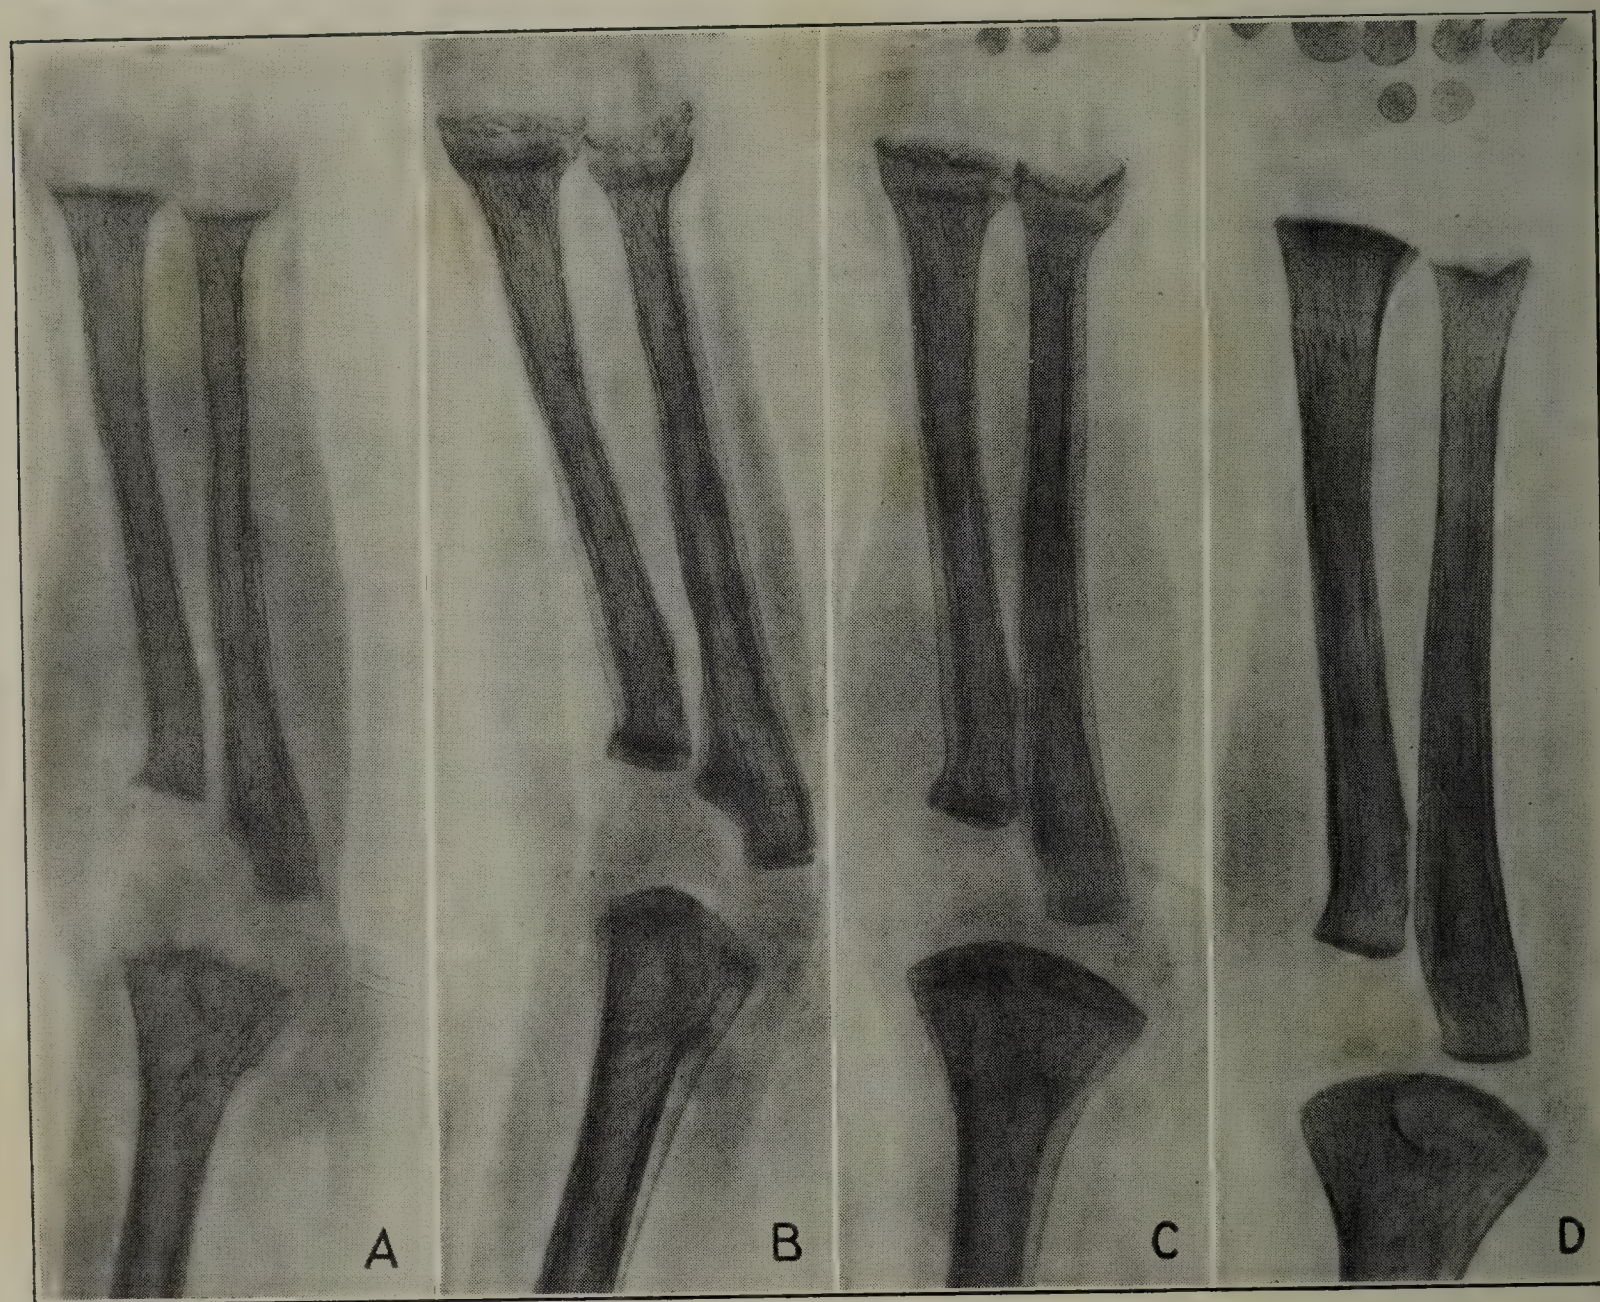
ROENTGEN-RAY APPEARANCE OF THE BONES IN RICKETS.
